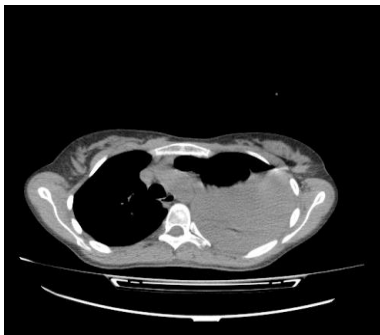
Spiral CT scan of the patient upon admission, showing moderate right-sided pleural effusion with adjacent lung consolidation, as well as severe left-sided pleural effusion with consolidation of the adjacent lung and a shift of the heart and mediastinum to the right.
